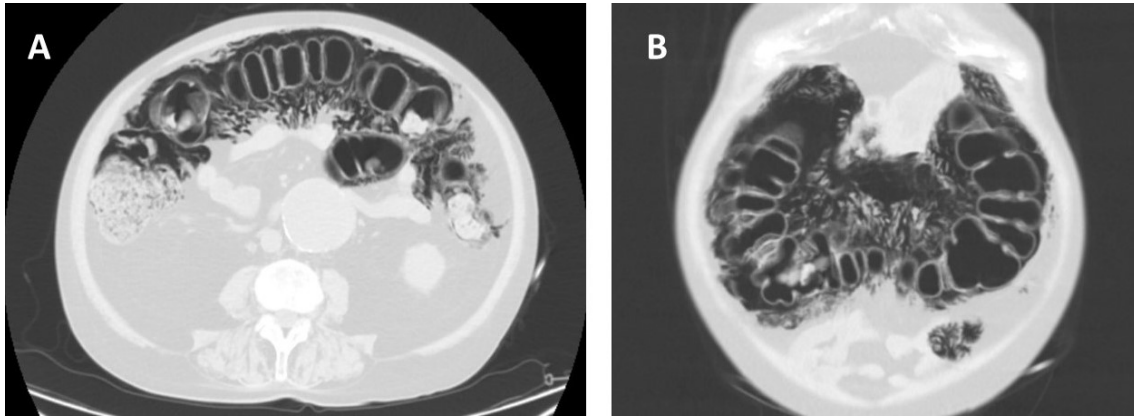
Axial (A) and coronal (B) plane of the CT scan shows an extensive colonic pneumatosis.
